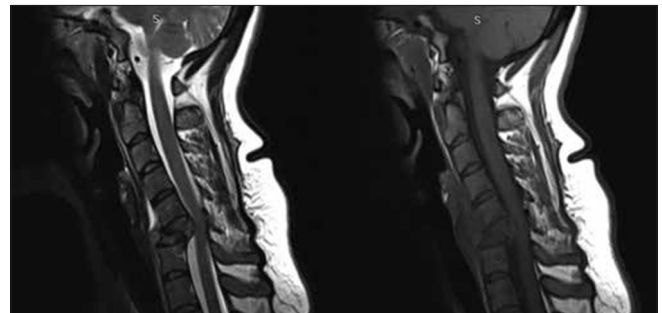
Magnetic resonance imaging shows vertebral plana of C6 with compressive effect on cord, but myelopathy was not detected
